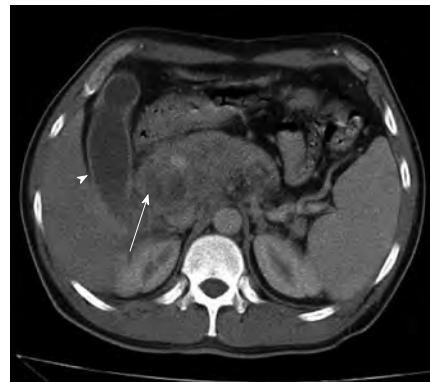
Contrast enhanced abdominal computed tomography. Head, body, and tail of pancreas with enlarged dimensions and a poorly-defined margin, with two hypodense areas without significant enhancement after intravenous contrast (white arrow). The same image shows a hydropic gallbladder (arrow head) and mild splenomegaly.
